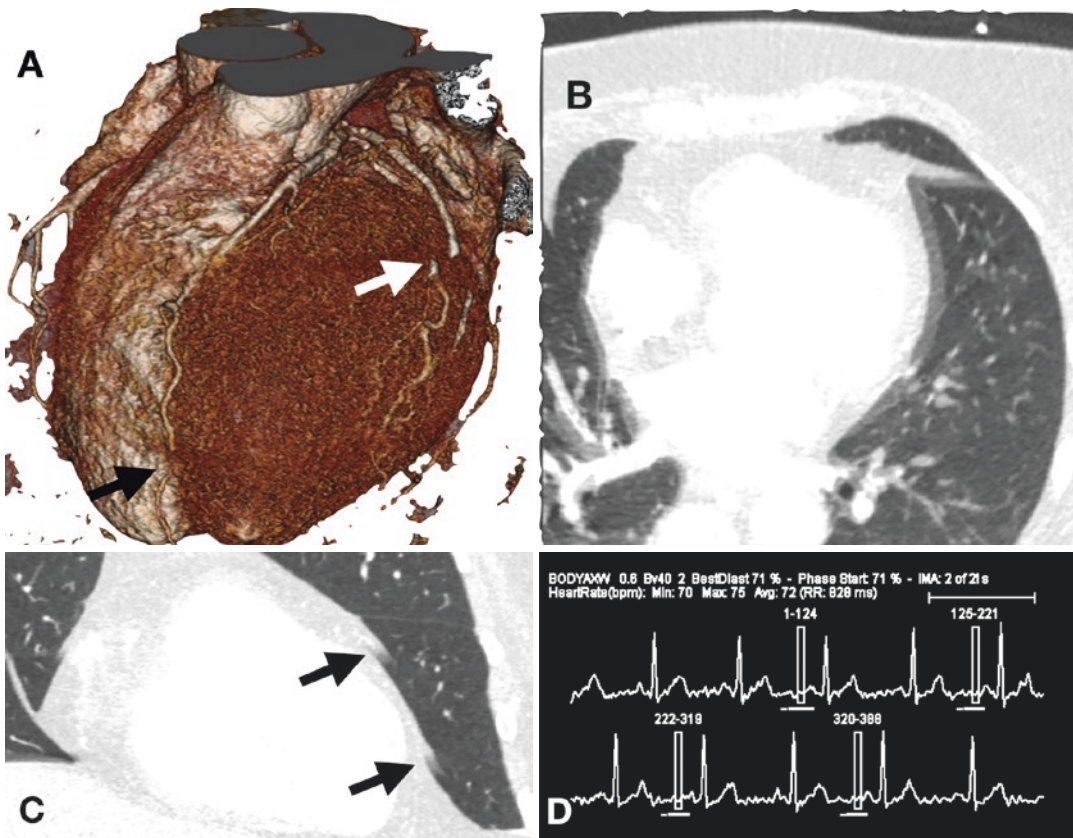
Prospectively triggered CT scan acquired during three heartbeats demonstrates misregistration between the slabs corresponding to the three beats (arrows) on a volume rendering (a) and coronal MPR (b). The transverse reconstruction in (c) is at the level of the lower
